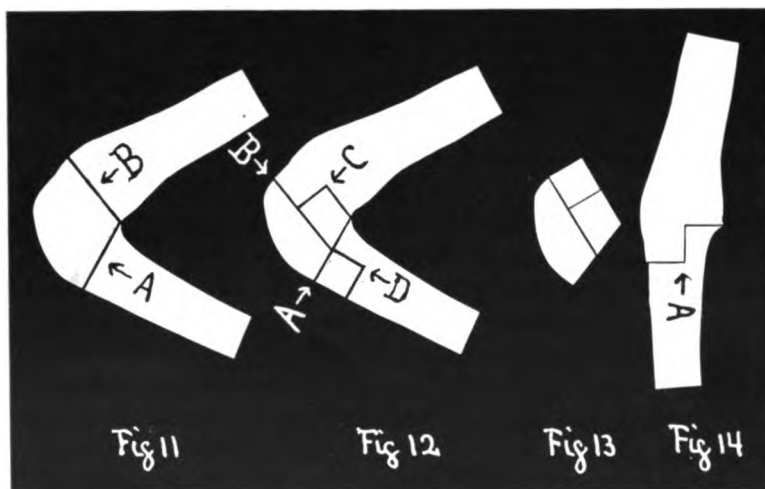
Tracing of radiograph, Fig. 10, showing cuts, A and B, that would have been necessary for a cuneiform osteotomy, and the resulting wedge fragment.
